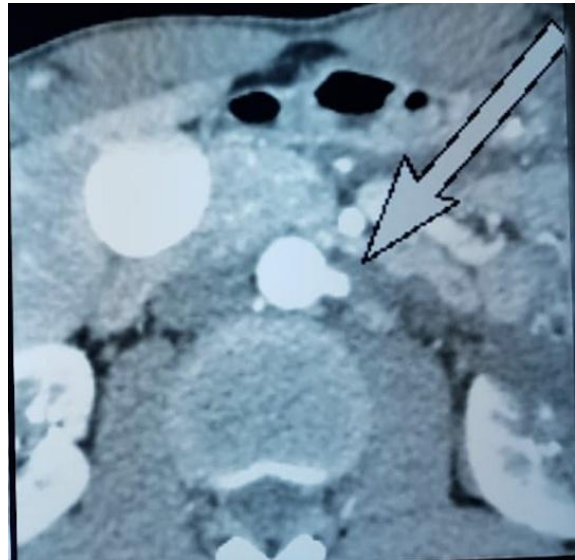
CT angiogram of the abdominal aorta showing total thrombosis of the accessory left renal artery
